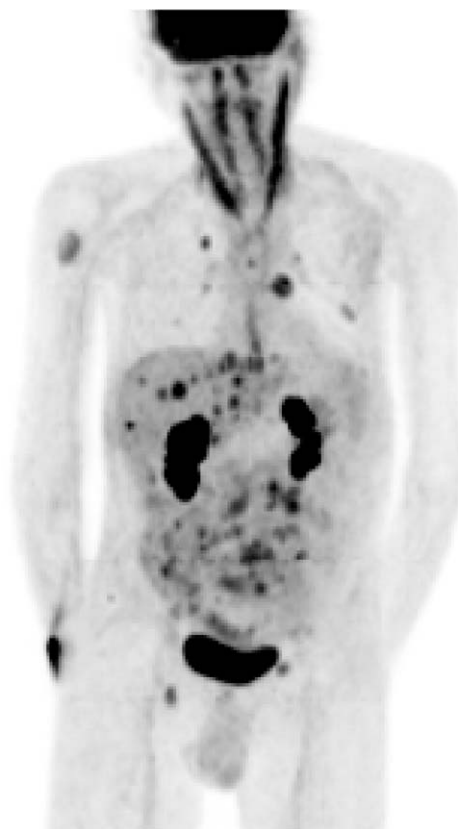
A 48-year-old man presented with weight loss, jaundice and anemia. A contrast-enhanced CT scan of the abdomen showed an unenhancing lesion in the uncinate process, with metastatic deposits only in the liver. The FDG-PET scan clearly demonstrated widespread metastases above and below the diaphragm. The exquisite tumor to background ratio exhibited by FDG-PET allows for accurate whole-body assessment of tumor burden.
